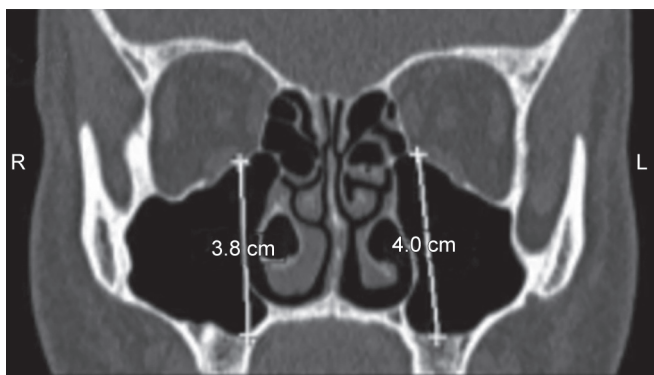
Coronal section of maxillary antrum CBCT image showing maximum SI dimension
